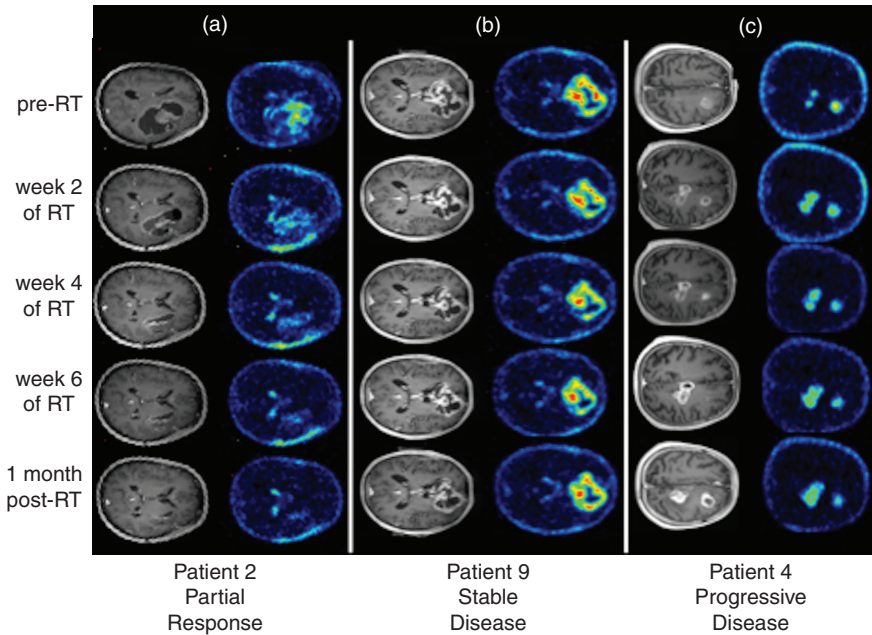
^{18}F -Fluoromethylcholine (^{18}F -FCho) PET and contrast-enhanced T1-weighted MR images in 3 GB patients (a,b,c). (a) A 47-year old female patient diagnosed with GB in the right frontal and temporal lobe. According to the RANO criteria the patient is categorized as a partial responder. A 60 % decrease in SUV_{max} and SUV_{mean} is observed from pre-RT to 1 month post-RT. (b) A 71-year old male patient diagnosed with a bifrontal GB. According to the RANO criteria, the patient was categorized as stable disease. From pre-RT to 1 month post-RT, SUV_{max} decreased 17 % while SUV_{mean} remained more or less stable. (c) A 66-year old male patient diagnosed with multifocal GB. A new lesion was visible on follow-up MRI, categorizing the patient as progressive disease. From pre-RT to 1 month post-RT SUV_{max} and SUV_{mean} decreased 52 % and 59 % respectively, while MTV increased with > 300 % (96).
